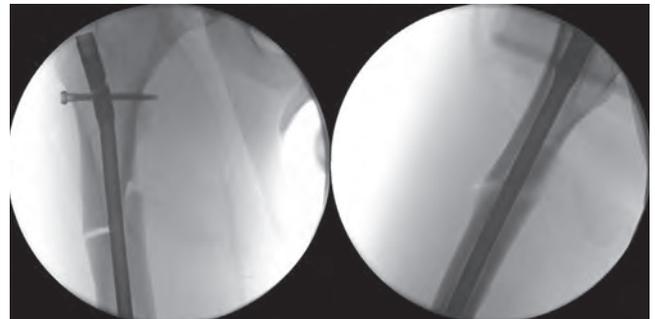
Intraoperative radiographs of right femur following closed reduction and intramedullary nailing.
